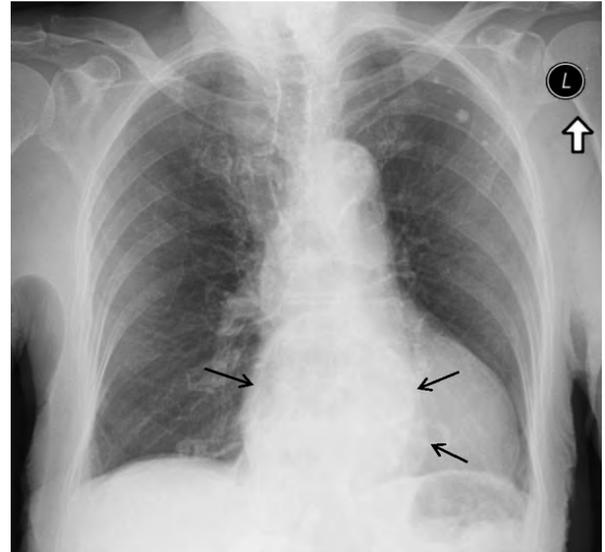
Posterior–anterior chest X-ray. An image of a large sliding hernia, with the gastrointestinal tract visible in the midline (arrows)
